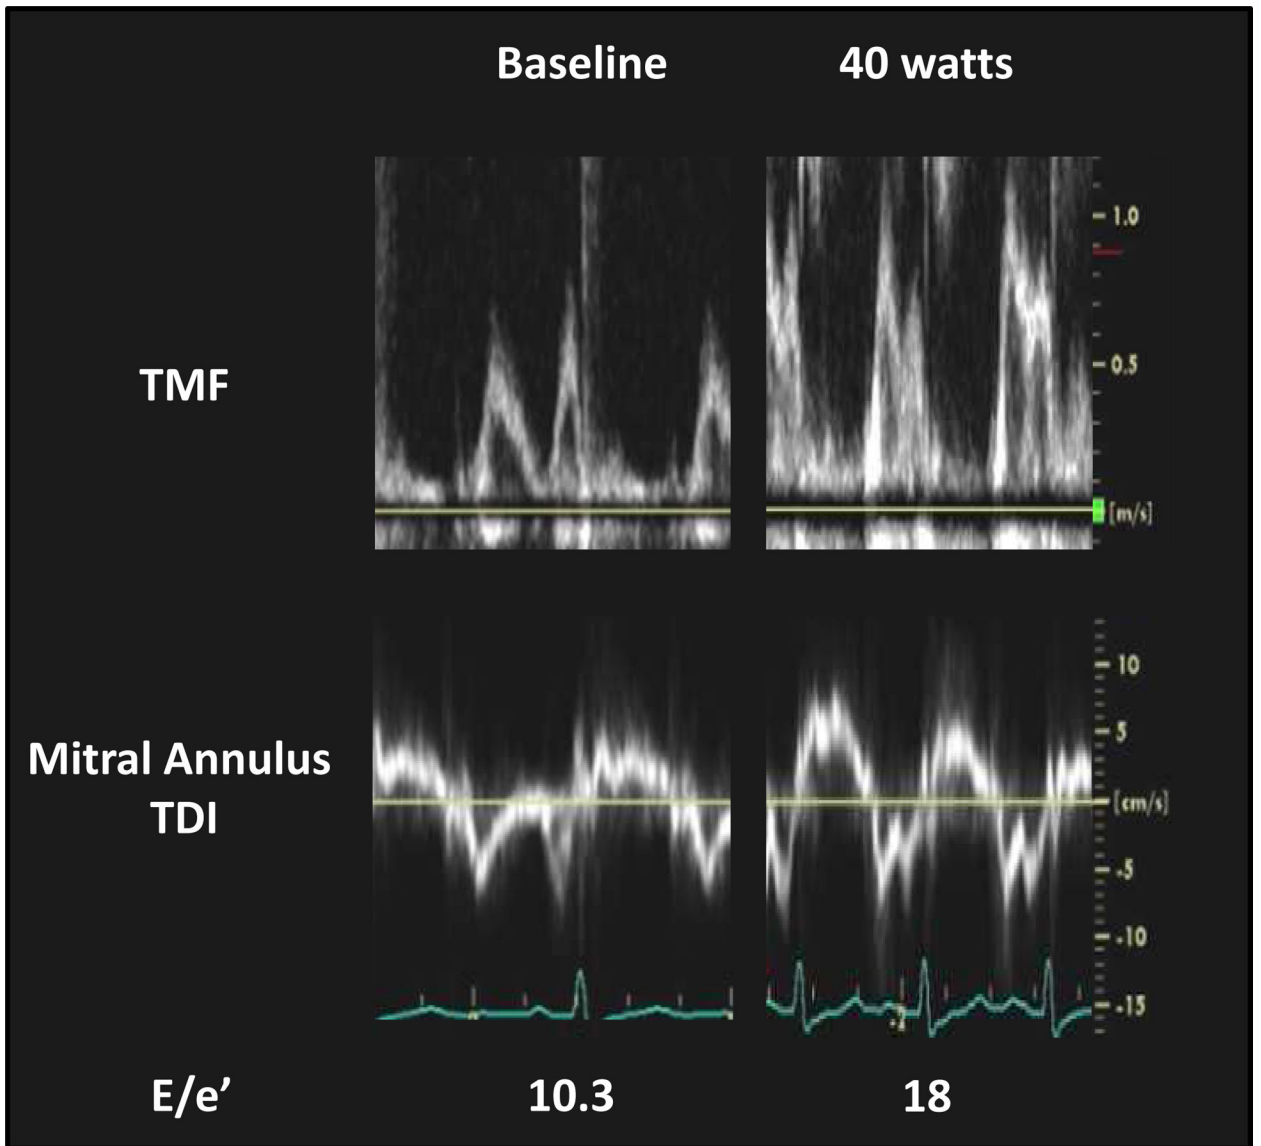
Typical Case of Diastolic Stress Echocardiography
